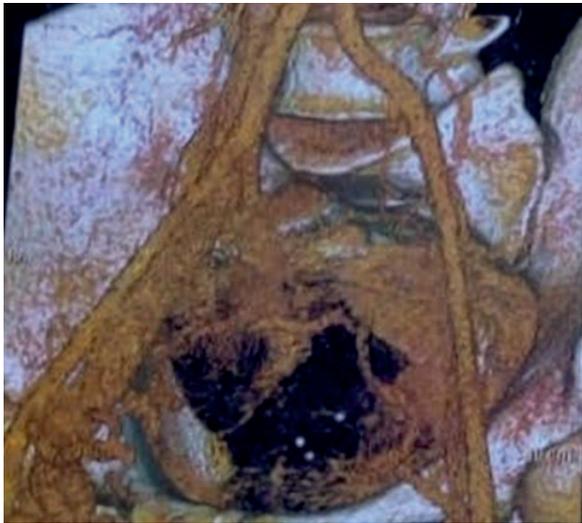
Abdominal-pelvic coronary computed tomography angiography showing the obstruction of the left iliac vein by the right common iliac artery at 5L vertebra level (May-Thurner syndrome).
